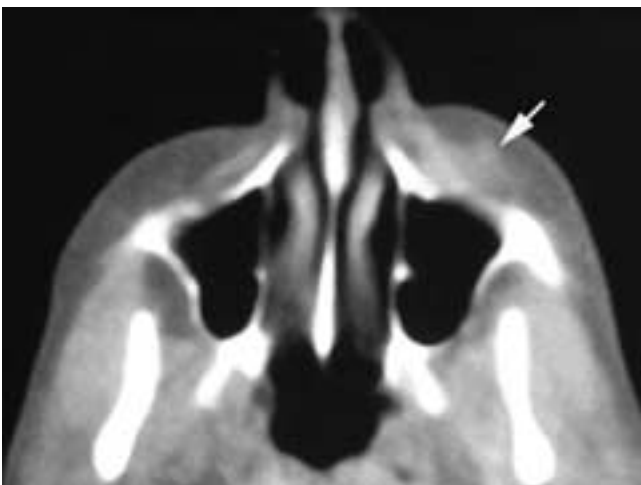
Axial CT scan shows a small soft tissue mass in the left cheek (arrow). The mass is within the subcutaneous tissues, adjacent to the anterior maxillary sinus wall. There was no bone erosion. This patient had a malignant granular cell tumor.
